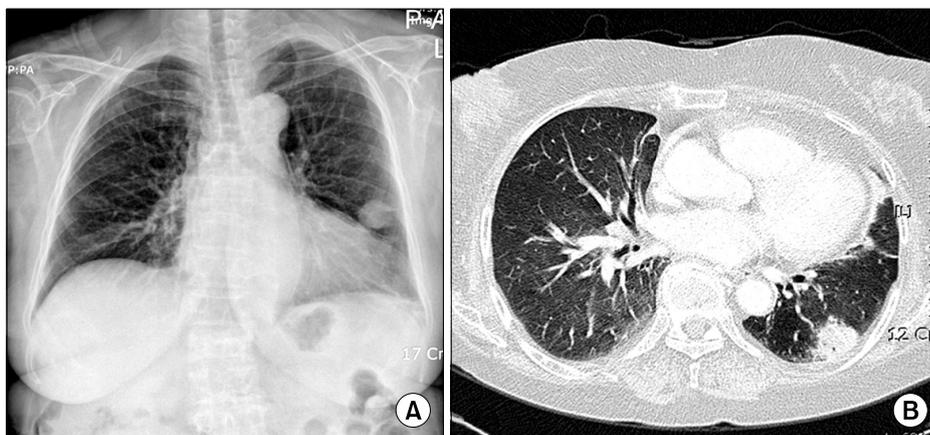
On admission, chest X-ray shows nodular shadow on the left lower lung field (A). Chest CT reveals a 3×3 cm sized nodule in the left lower lobe of the lung with underlying bronchiectasis (B).
